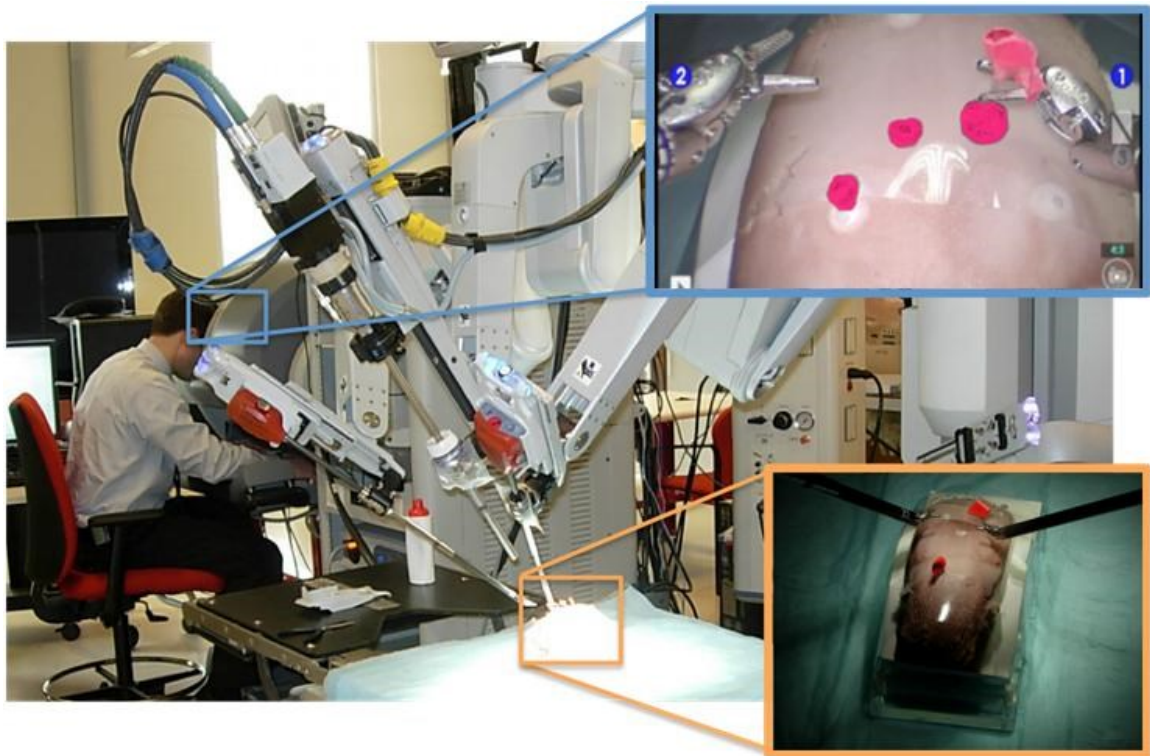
Experimental setup using a *da Vinci S* system with stereoscopic video overlay of spherical soft-tissue targets (magenta) segmented from intraoperative CBCT.
